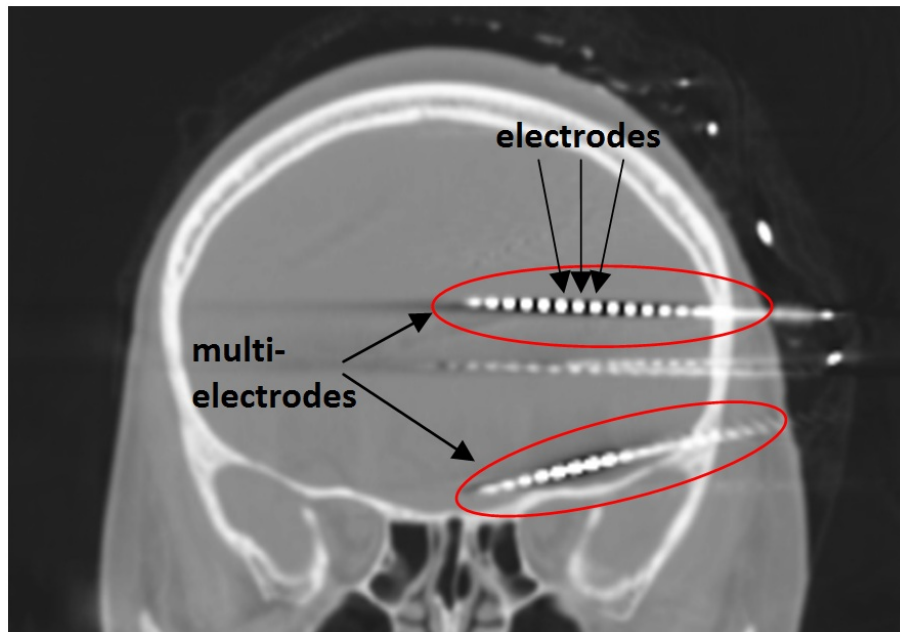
CT image of depth electrodes implantation scheme.
